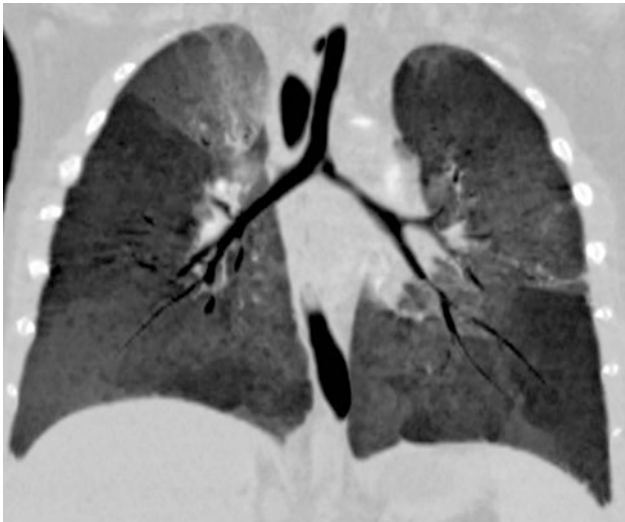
Lung over-inflation secondary to an obstructive bronchogenic cyst. One-month-old boy with respiratory distress a On chest X-ray, there is over-inflation of the right lung with mediastinal displacement to the opposite side. A mediastinal mass can be seen on the right side. b Enhanced axial CT shows a hypodense mediastinal mass on the right side, with substantial over-inflation of the right lung, and mediastinal and lung displacement to the left side. c Axial CT B60f for high-resolution
